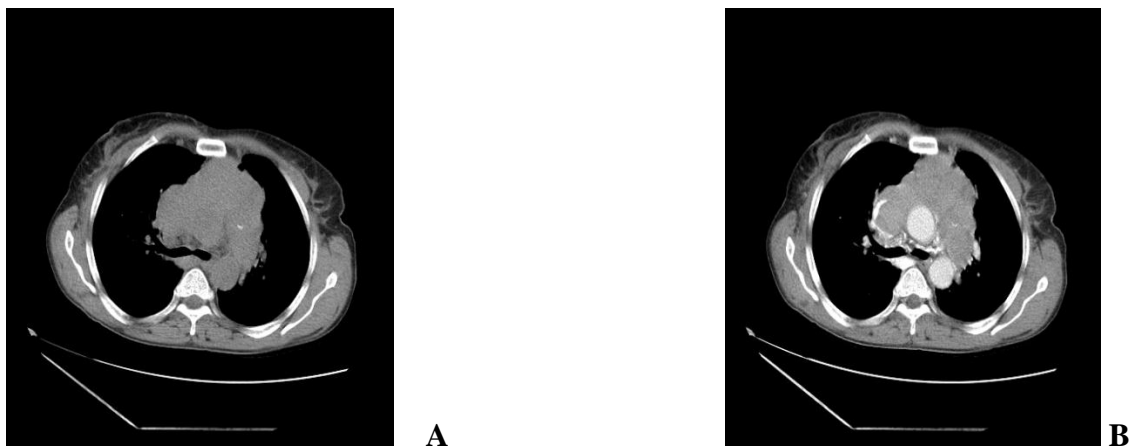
(A and B): Axial section-pre and post contrast CT of chest showing Thymoma
